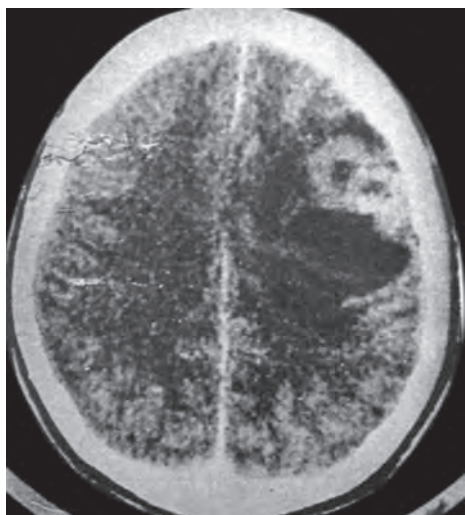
Contrast CT scan showing a parietal tuberculoma with a posterior cystic component
